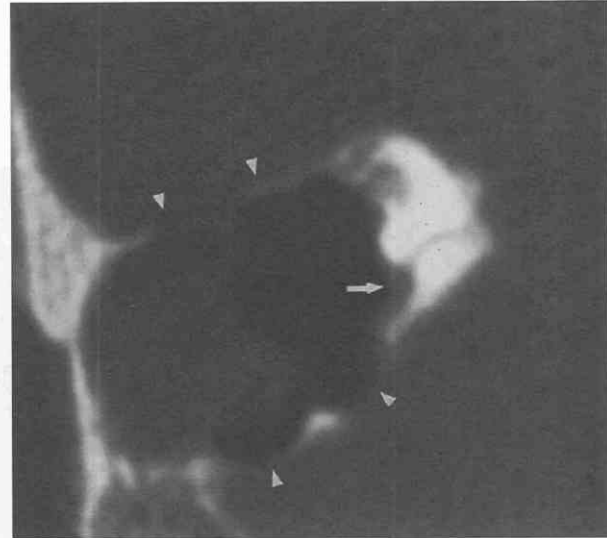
Autoantrectomy. Axial CT section through the right superior temporal bone. There is a large defect in the mastoid with thinning of the bony margins (arrowheads). A central soft tissue mass partially fills the space. This patient did not have surgery, but the cholesteatoma has almost completely emptied the mastoid space as a result of chronic bone destruction. There is erosion of the superior semicircular canal (arrow).
